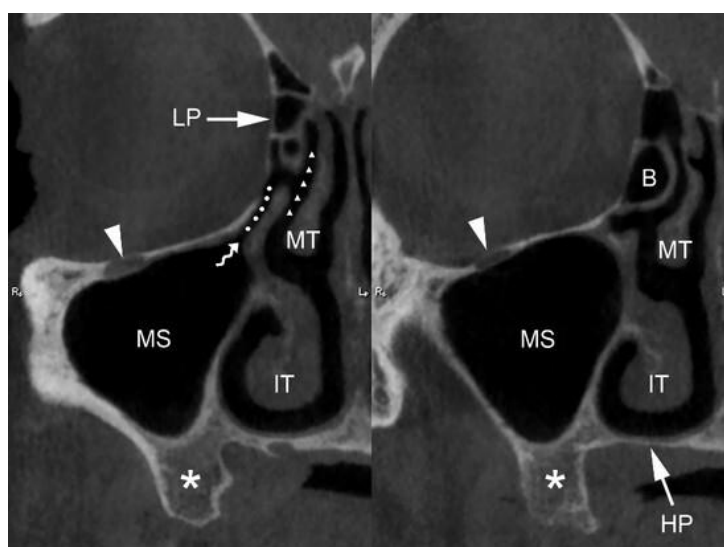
Cross-sectional CBCT images at the level of the ostiomeatal complex, showing the infraorbital canal (arrowhead), maxillary sinus ostium (wavy arrow), ethmoidal infundibulum (dotted line), middle meatus (small triangles), and maxillary alveolar process (asterisk). B, ethmoidal bulla; HP, hard palate; IT, inferior turbinate; LP, lamina papyracea; MS, maxillary sinus; MT, middle turbinate. Source: *Sinonasal Complications of Dental Disease and Treatment: Prevention–Diagnosis–Management*. Felisati G, Chiapasco M, ed. 1st Edition. Stuttgart: Thieme; 2015. doi:10.1055/b-006-149711
